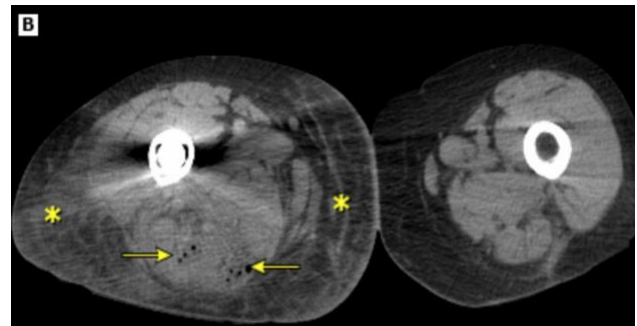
CT scan showing gas bubbles (arrows) and circumferential edema (asterisks).
